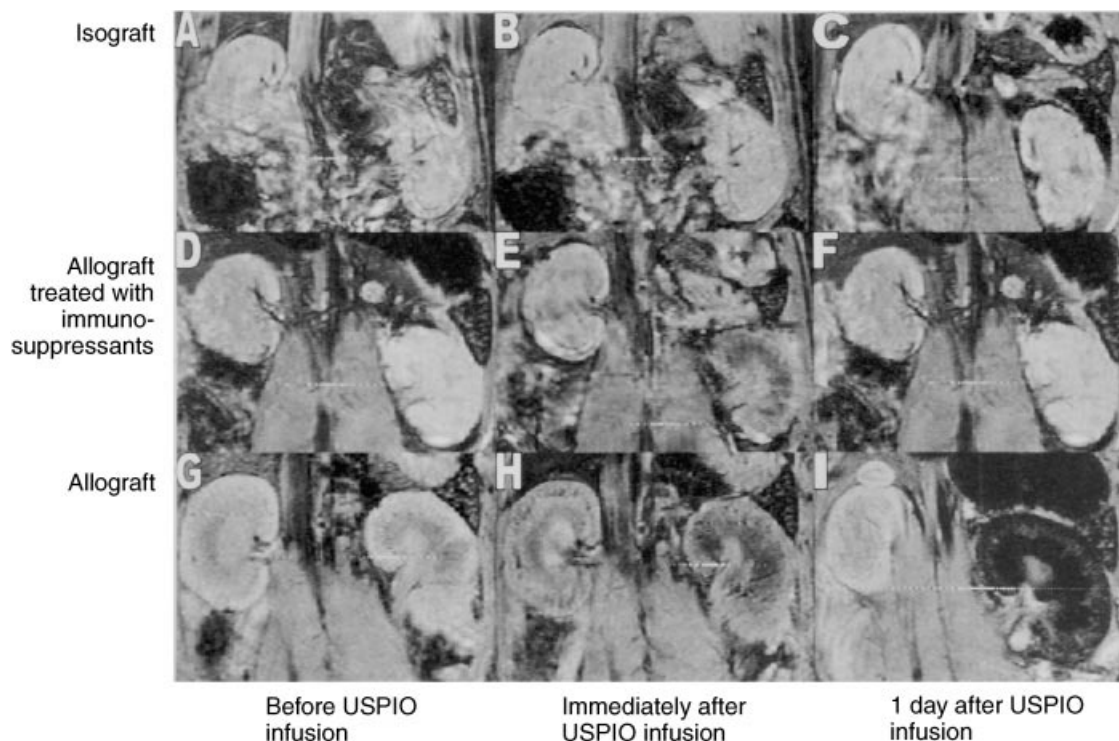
Gradient-echo MR images showing the effect of USPIO infusion. (A–C) Images from an isograft study immediately before (A) and immediately after (B) USPIO infusion at POD 4, as well as one day following USPIO infusion (C) at POD 5. Images in (D–F) are from an allograft experiment with a triple immunosuppressant treatment at corresponding time points and (G–I) are from an allograft study without immunosuppressant treatment. In these panels, the transplanted kidneys appear on the right, and the native kidneys appear on the left. The allograft study without the immunosuppressant treatment (I) shows a decrease of the MR signal intensity within the transplant at one day after USPIO infusion. This decrease in MR signal intensity is believed to be due to an accumulation of macrophages containing USPIO particles in the rejecting transplanted kidney.
